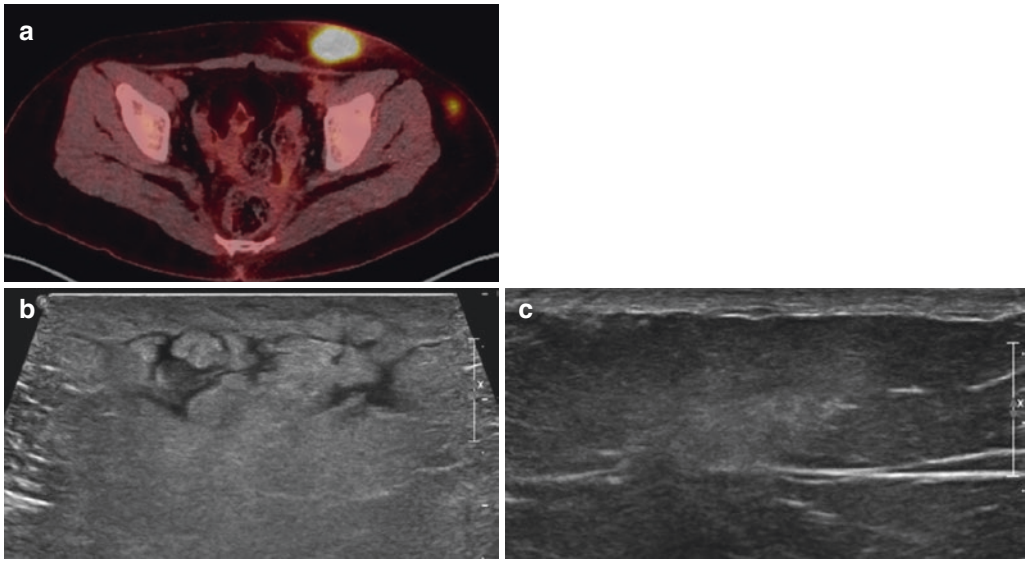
Panniculitis-like T-cell lymphoma. PET-CT image (a) shows two subcutaneous masses with intense FDG uptake in the abdominal wall. The corresponding US obtained in the left anterior abdominal wall (b) reveals
